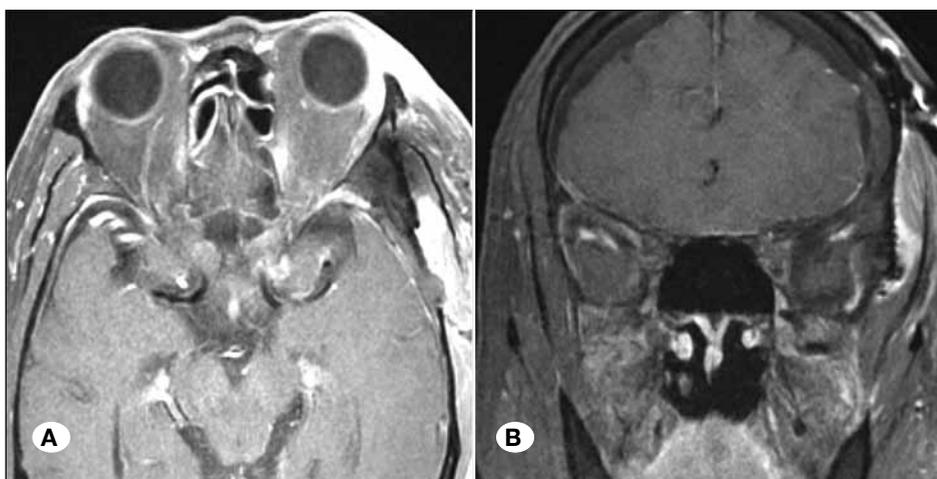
A, B) Postoperative Gadolinium-enhanced axial and coronal MRI showing no residual tumor.
